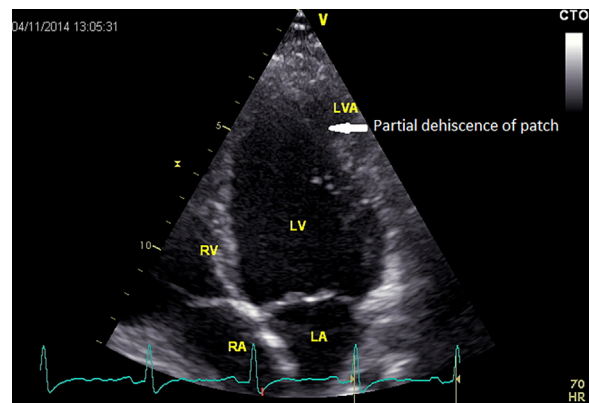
Apical four chamber view of left ventricle showing recurrence of the aneurysm and partial dehiscence of the patch.
